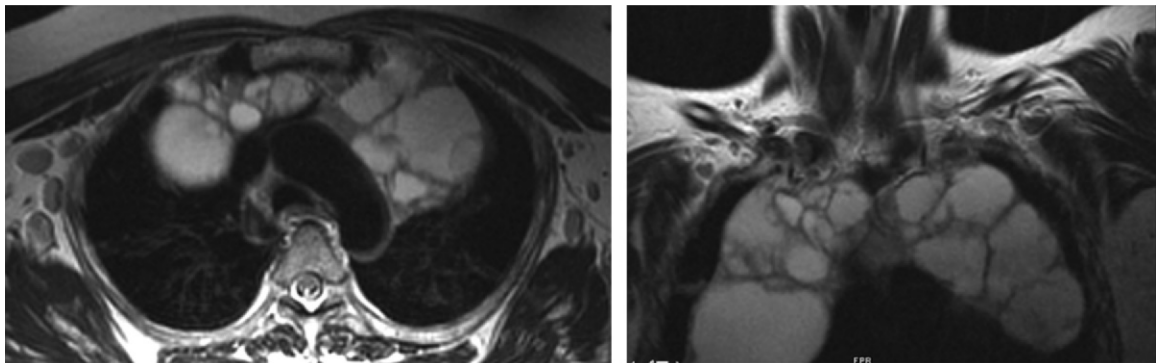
MTC in a patient with HIV infection. Axial (a) and coronal (b) T2-weighted MR images demonstrate a hyperintense MTC with septations in the superior mediastinum. (Courtesy of Daniel Ocazonez, MD, University of Washington, Seattle, and Carlos Restrepo, MD, University of Texas Health Science Center at San Antonio.)
